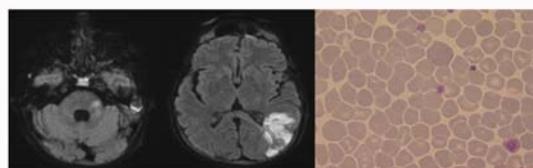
Cerebral MRI (diffusion weighted imaging) and peripheral-blood smear (elevated red blood cell count).
